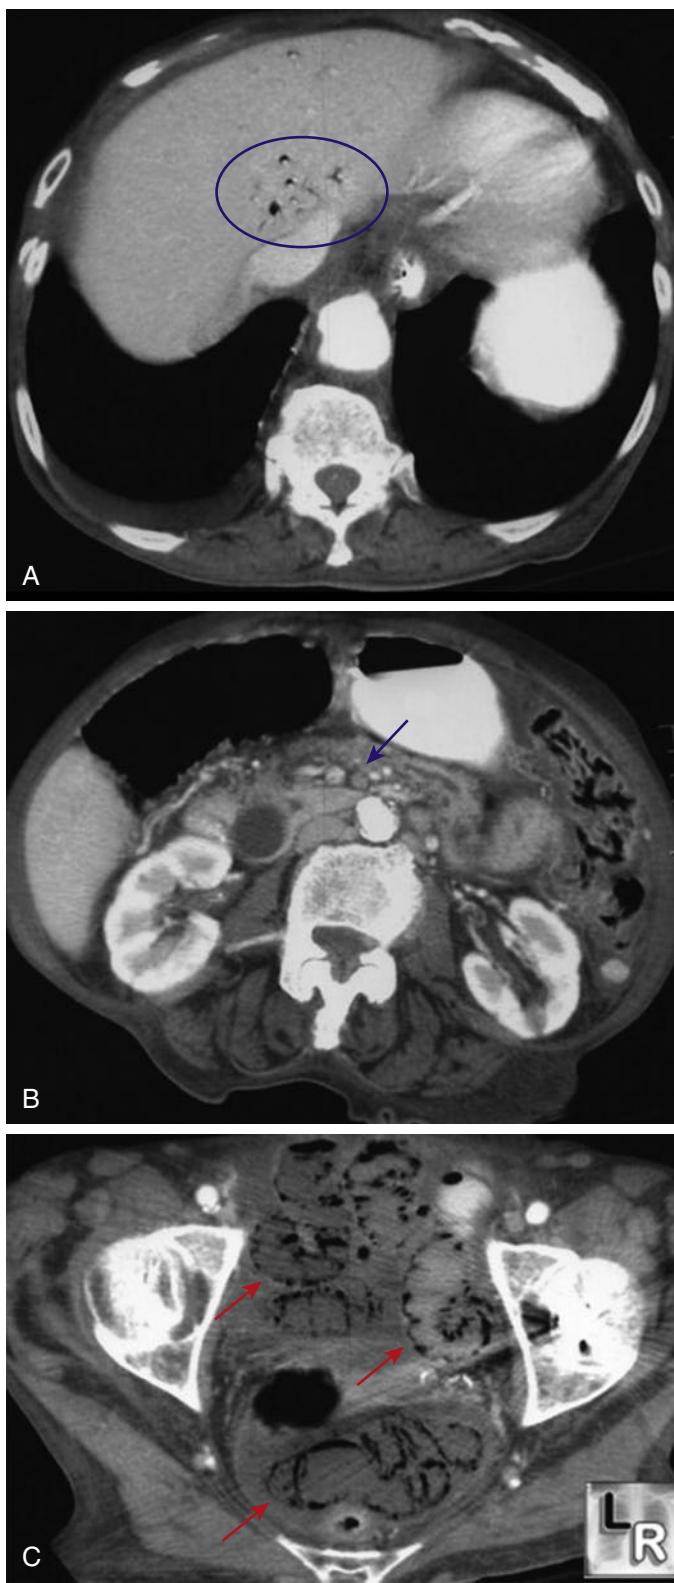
(A) Computed tomographic angiography demonstrating hepatic venous air (circle). (B) The superior mesenteric artery is occluded (arrow). (C) There is extensive colonic pneumatosis and ascites (arrows). (From: <http://www.learningradiology.com/notes/ginotes/mesentericischemiapage.htm>.)
